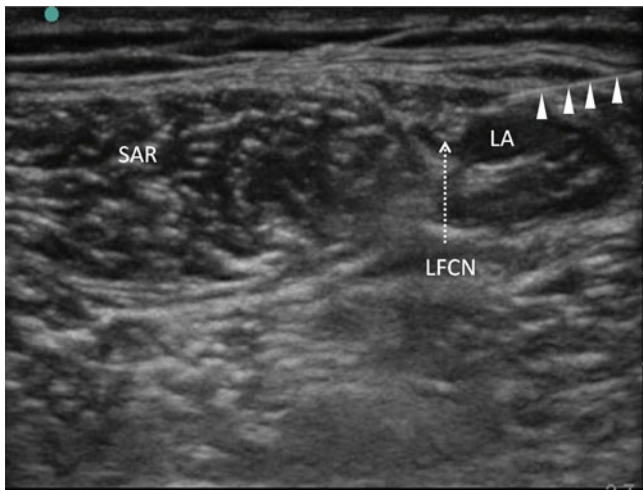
Post-injection ultrasonographic picture of LFCN; the needle was inserted in-plane and was indicated by *arrowheads*; *LA* local anesthetic, *SAR* sartorius muscle (Reproduced with permission from Philip Peng Educational Series)
